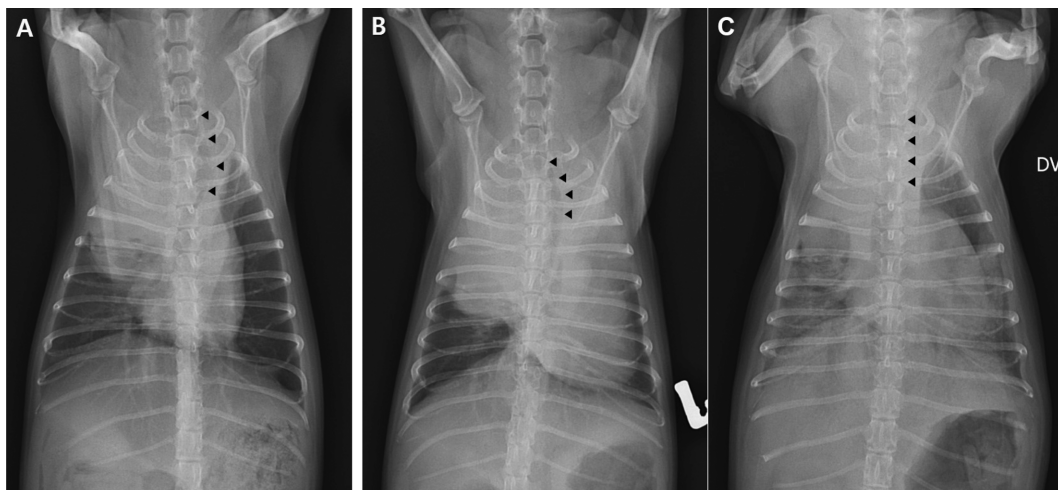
Ventral dorsal view of the thorax. (A) Radiography obtained upon admission reveals a primary pulmonary mass on the right cranial side. (B) Ten days after the first visit, radiography reveals that the mass enlarged compared to that in the previous image. (C) Taken 17 days after administering the oral medication (the day the patient died), the radiography reveals that the mass appeared smaller in size than before, and the trachea and mediastinum had returned to their normal position with pulmonary edema. ◄; trachea position.
